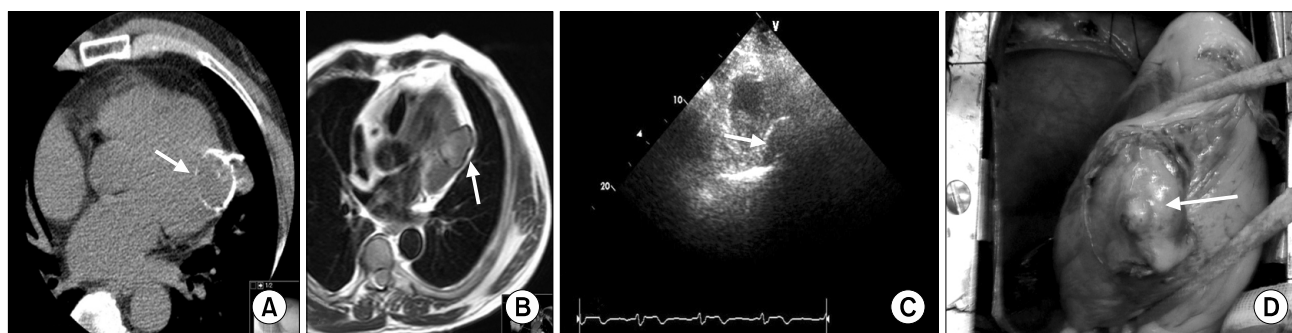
(A) Thorax computed tomography showed a cystic lesion on the left ventricle anterolateral wall. (B) Cardiac magnetic resonance imaging showed a cystic lesion on the left ventricle anterolateral wall. (C) Echocardiographic appearance of the hydatid cyst on the left ventricular anterolateral wall. (D) View of the cystic membrane on the left ventricle anterolateral wall.
